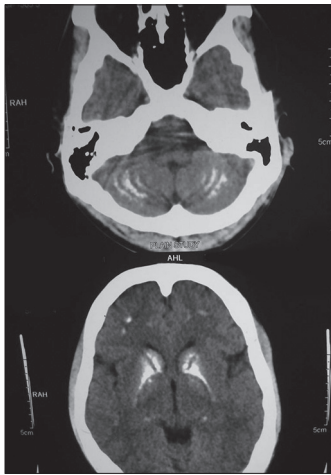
Computed tomography of the brain showed bilateral extensive calcification involving the thalamus dentate nuclei, putamen globus pallidus, caudate nucleus, subcortical white matter, as well as the cerebellum
